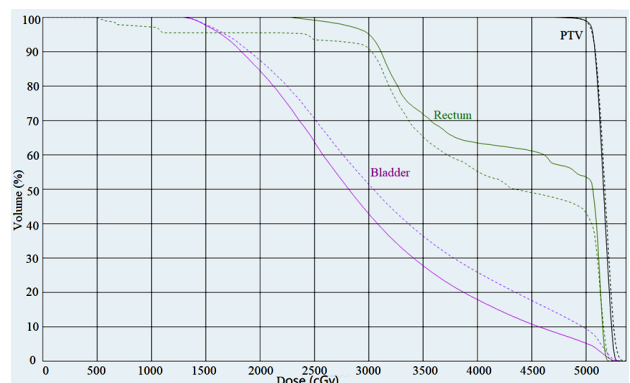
DVH values computed using between the SCT and real CT images for one example patient.
